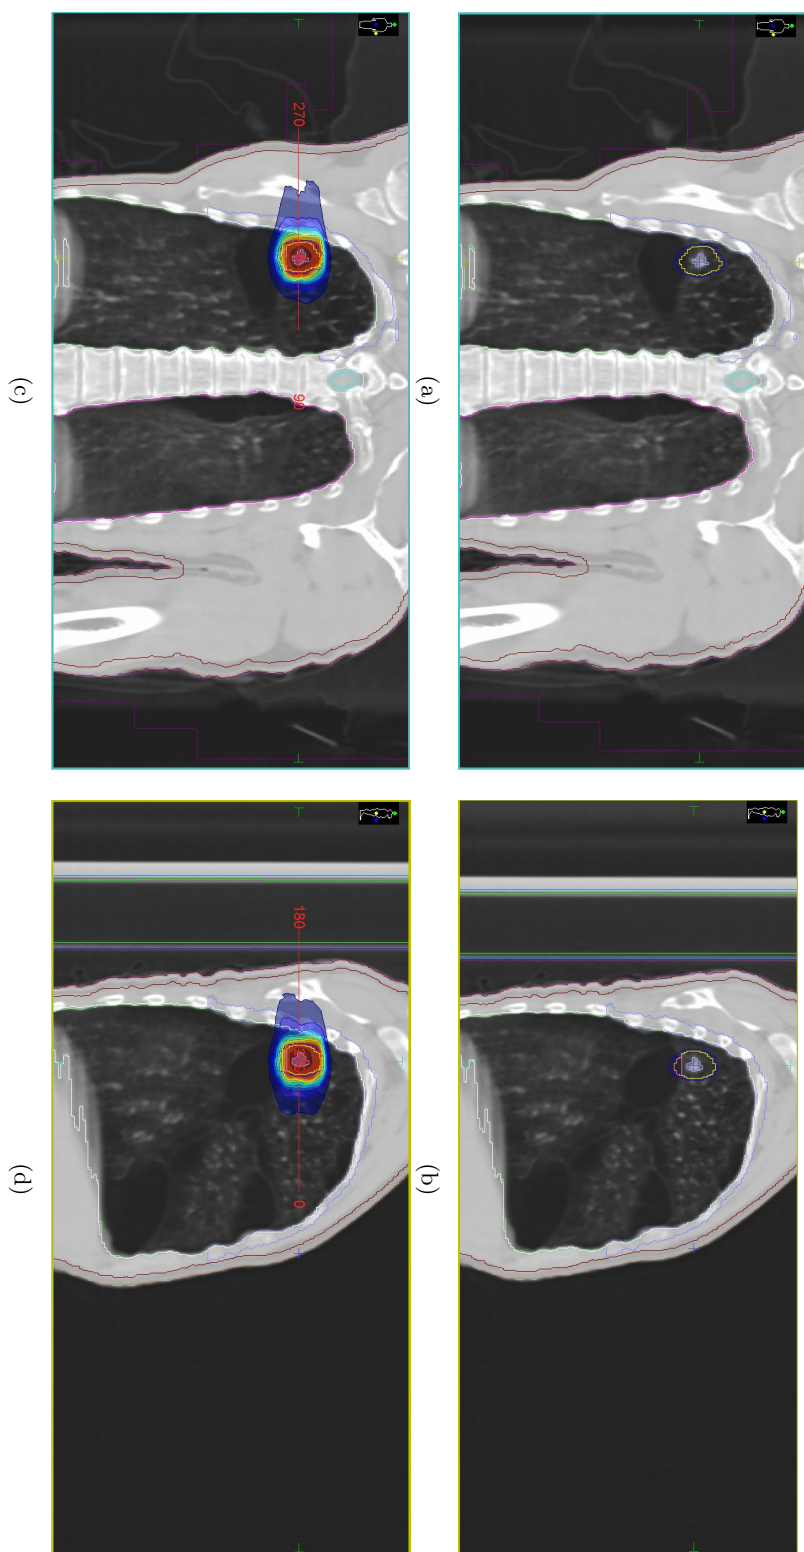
Case Study Patient CT scan, taken from Monaco 5.1: (a) The coronal view of the NSCLC, showing the contoured ITV and PTV, and the overlap of the air bubble and PTV. (b) The sagittal view of the NSCLC. (c) The coronal view of the dose distribution of the original DCAT plan. (d) The sagittal view of the dose distribution of the original DCAT plan.
